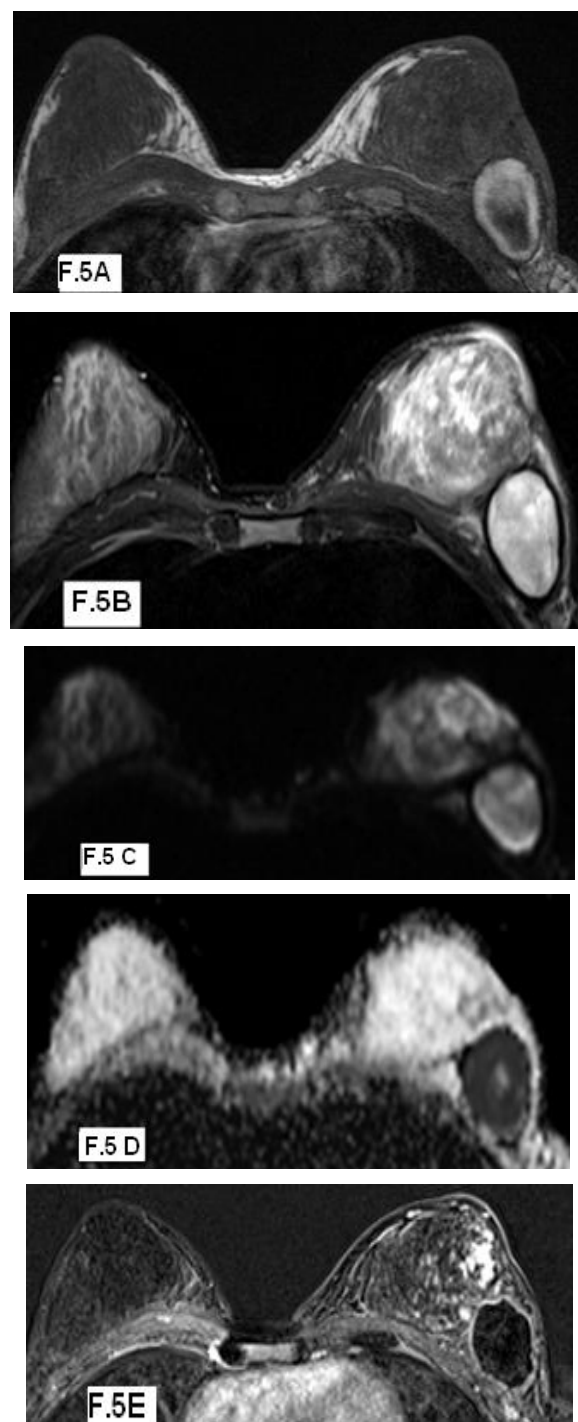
Hematoma. 29 year-old female submitted to left lumpectomy 6 months ago for ductal carcinoma. (A) Axial T1WI displays left breast mass of central low signal intensity and peripheral hyperintensity, (B) T2 FS demonstrates left breast hyperintense mass. (C) DWI with $b= 800$ shows hyperintense lesion. (D) The ADC map shows hypointense lesion with ADC value of about $0.39 \times 10^{-3} \text{ mm}^2/\text{s}$. (E) Post-contrast GRE (VIBE) shows marginal enhancement
